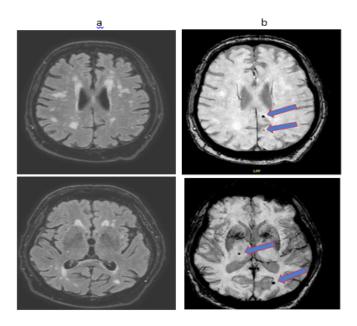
Magnetic resonance imaging (MRI): a) FLAIR sequences showing white matter hyper intensities b) Susceptibility Weighted Image (SWI) sequences demonstrating microbleeds (around the calcarine fissure on the right side of the image (left side of the patient). The image was read by radiology as "moderate to severe chronic microangiopathy, mild to moderate generalized volume loss, and multiple microhemorrhages".
